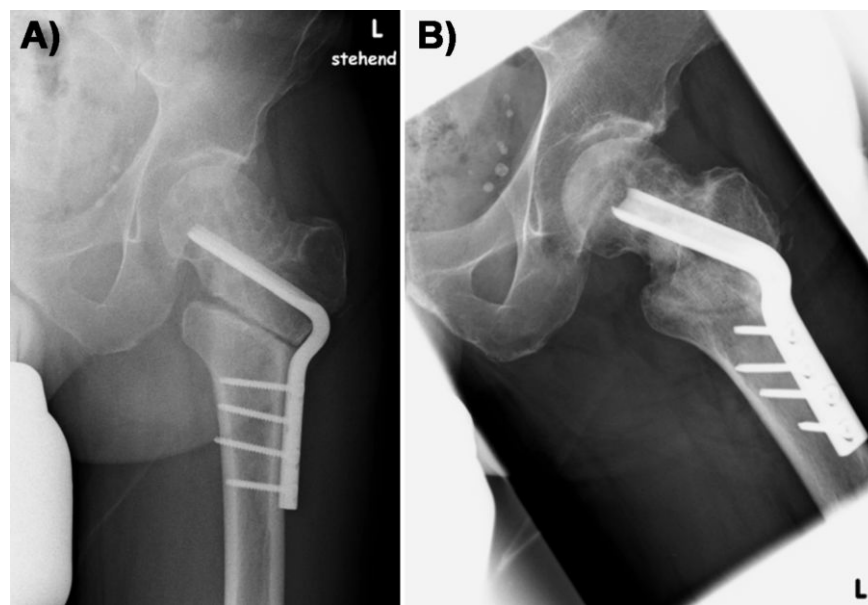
Anteroposterior (A) and lateral (B) radiographs of the left femur 2.5 months after derotational open-wedge osteotomy and before extracorporeal shock-wave therapy show no sign of ossification or calcification in the osteotomy-gap.
